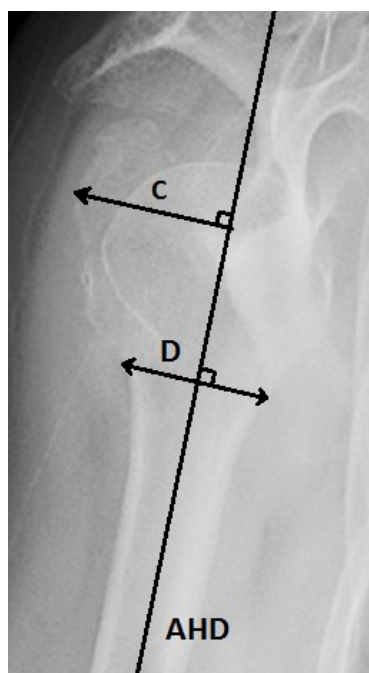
Measurement of the GT Ratio on Plain Radiography for Anterior/Posterior Displacement
